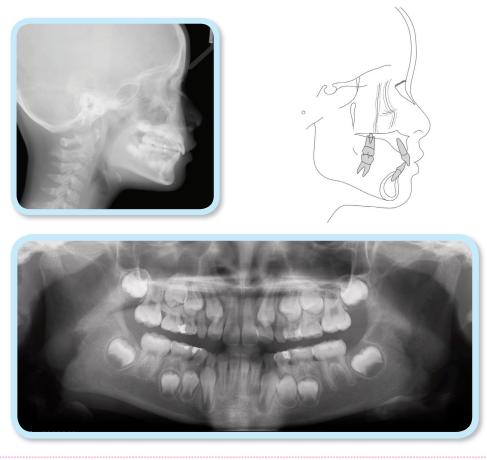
Pre-treatment lateral cephalometric radiograph with tracing, and the initial panoramic radiograph
